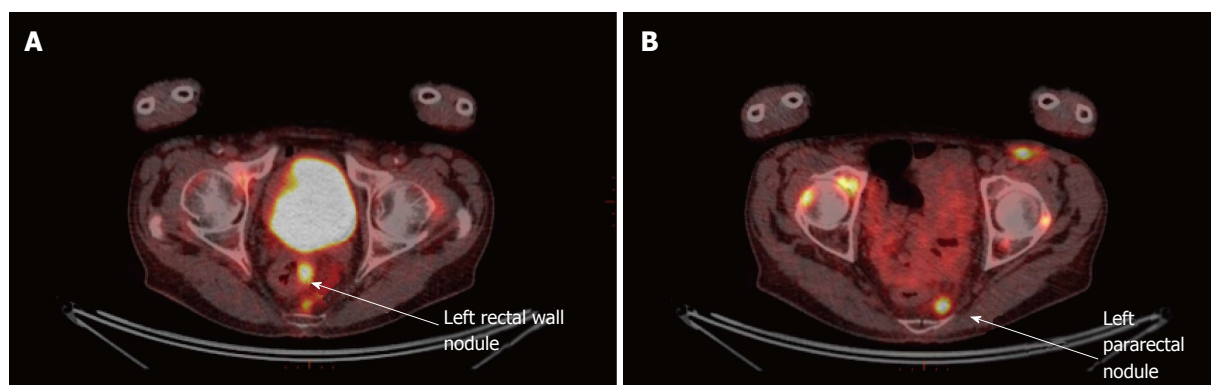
The positron emission tomography-computed tomography: Left rectal wall nodule (A) and left pararectal nodule (B).
